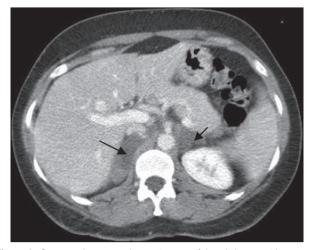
Computed tomography angiogram of the abdomen with contrast showed bilateral hypodense adrenal enlargement suggestive of adrenal infarct
